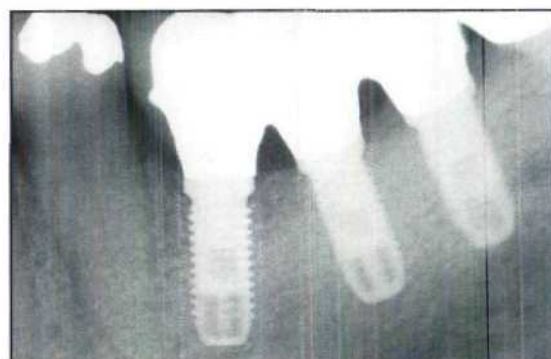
Six-year periapical radiograph of the functioning implants. Note the bone condensation around the cervical area of the anterior implant.
